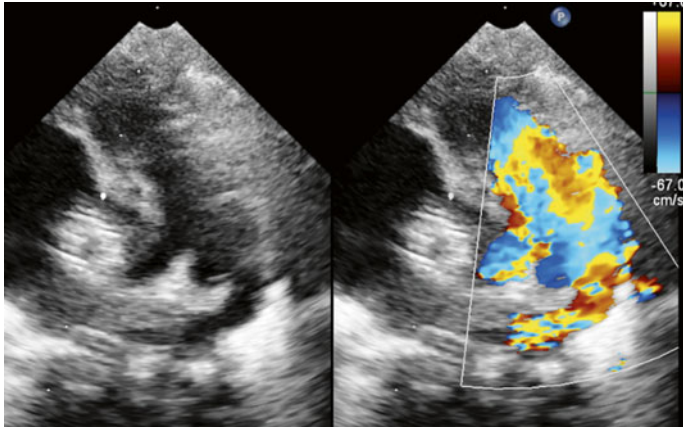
Echocardiography evaluation of duct morphology, in terms of its length and width and its relationship to the descending aortic arch
